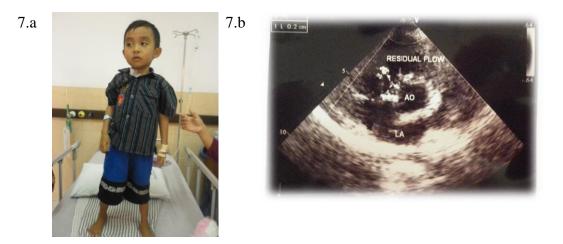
a) Clinical patient 3 days after surgery, b) Echocardiography showing postoperative residual VSD
